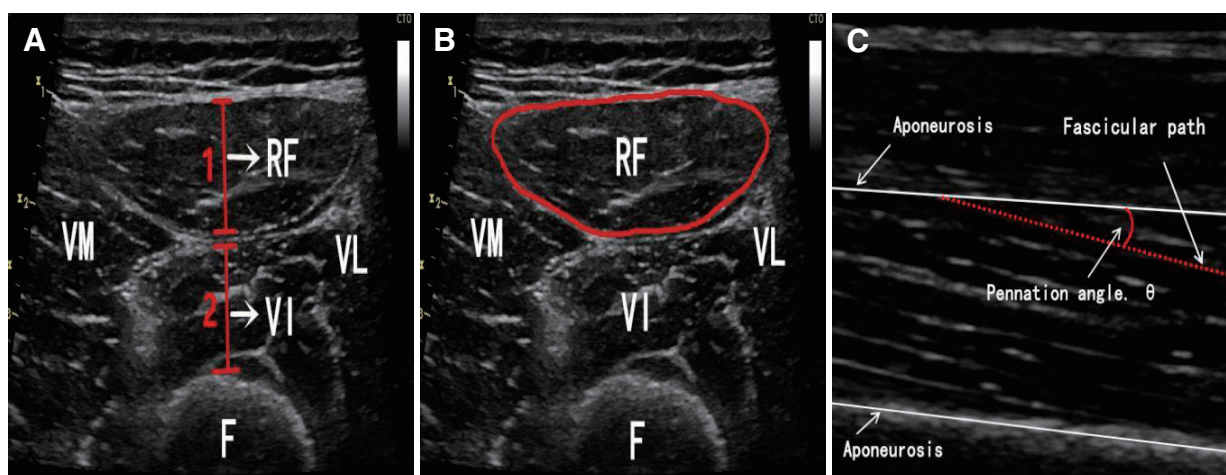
Muscle measurements based on ultrasound images. (A) Muscle TH of RF layer and intermedius femoris layer, (B) CSA of RF, and (C) PA of RF. CSA: cross-sectional area; F: femur; RF: rectus femoris; VI: vastus internus; VL: vastus lateralis; VM: vastus medialis; PA: pennation angle; TH: thickness
